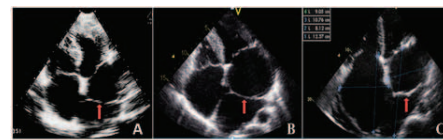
Transthoracic echocardiography apical 4-chamber views revealing a membrane (arrow) subdividing the left atrium into two chambers. The dynamic of heart changes throw the years 1995 (A), 2007 (B), 2014 (C).
